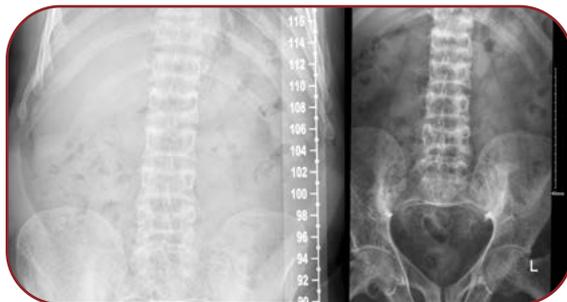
Spine X-ray showing Rugger Jersey spine
